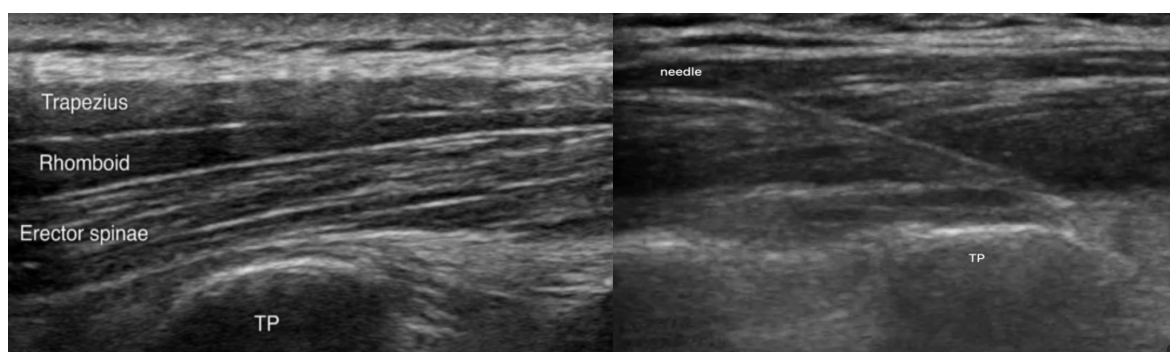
A (anatomical ultrasonography view of all structures), B (needle insertion and position)
